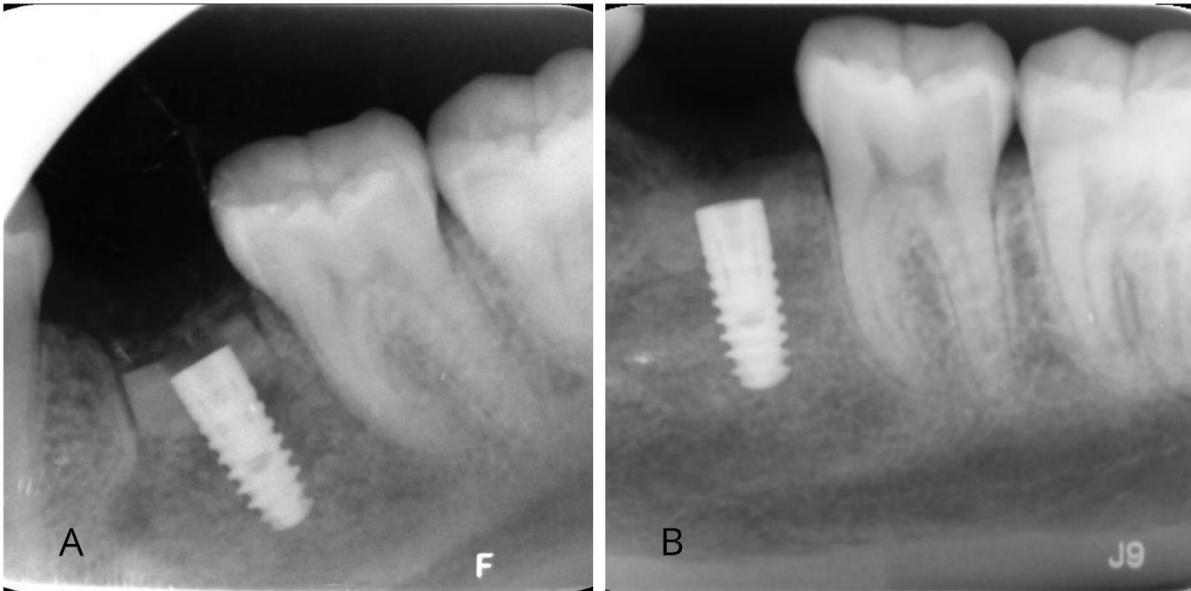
Postoperative periapical radiograph at 1st month (A) and 3rd month (B)
